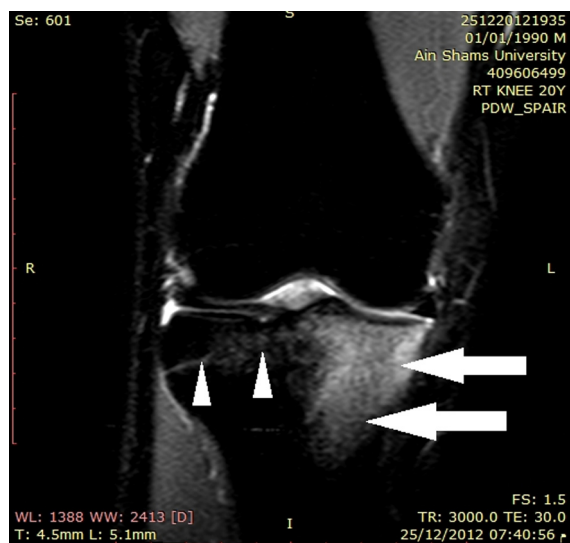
Coronal PDW-SPAIR knee MR image demonstrating medial tibial plateau bone marrow contusion, exhibits high signal intensity (arrows), with underlying medial tibial plateau transverse fissure fracture (arrows heads).
